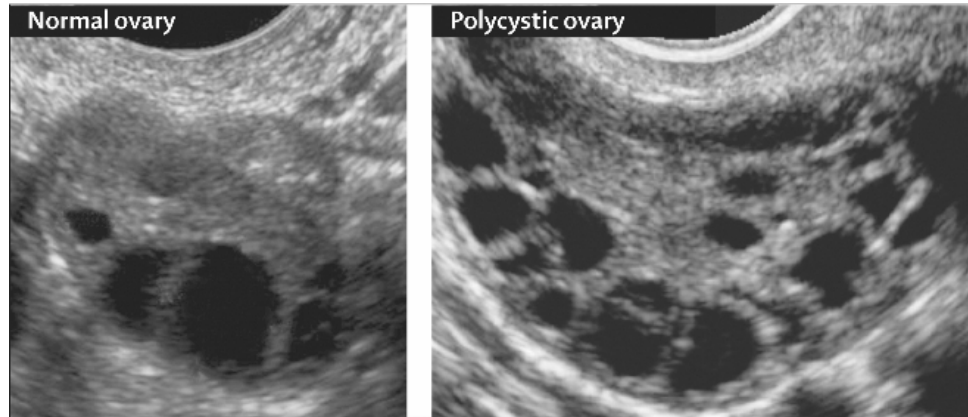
An ultrasound scan of a normal and polycystic human ovary.
